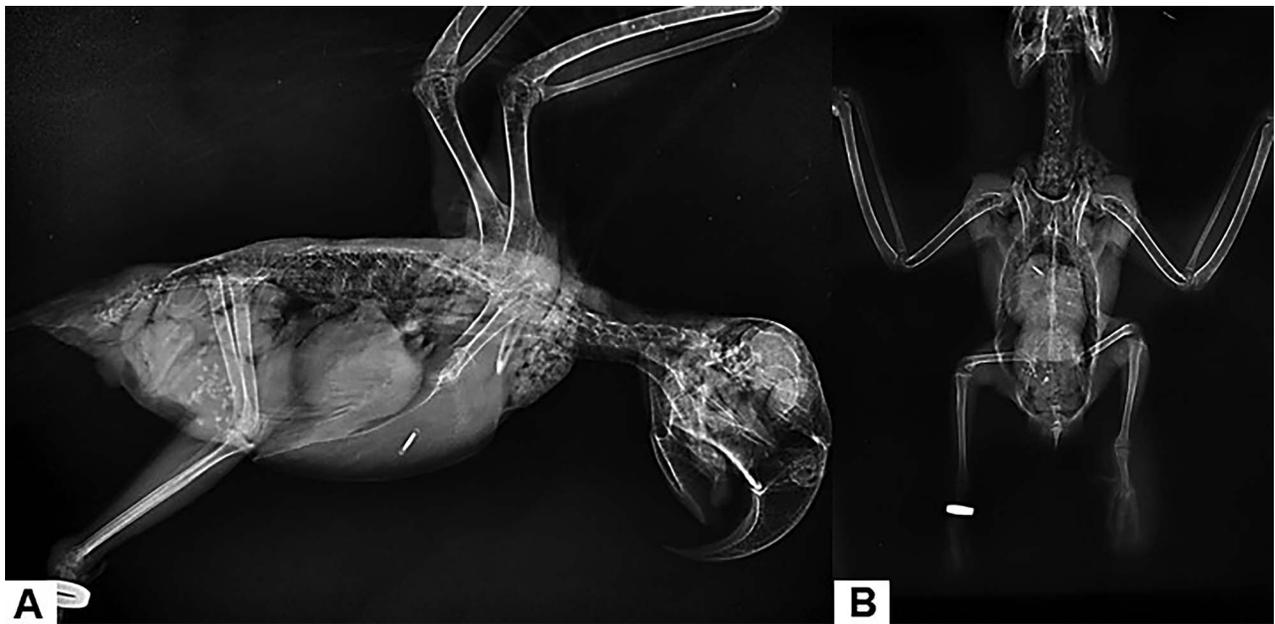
Radiographic images of the Lear's macaw (*Anodorhynchus leari*) that had dyspneic episodes and died while anesthetized. (A) Lateral view. (B) Ventrodorsal view.
